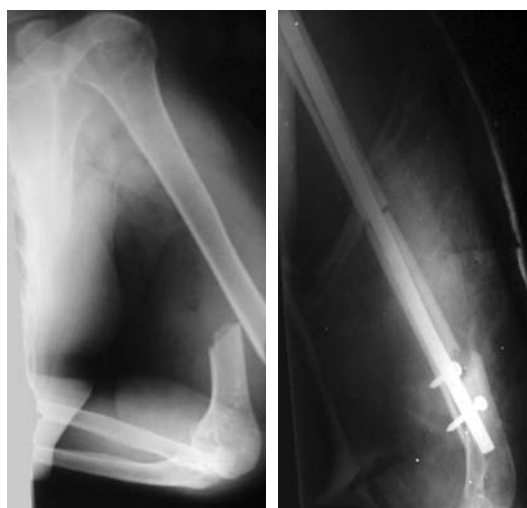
2A. Radiographic appearance of humeral diaphyseal fracture, type C1, in a 63 year-old patient. 2B. Details of the osteosynthesis with blocked intramedullary nail (Flexnail-type) through retrograde port. 2C. Final outcome showing fracture union.
